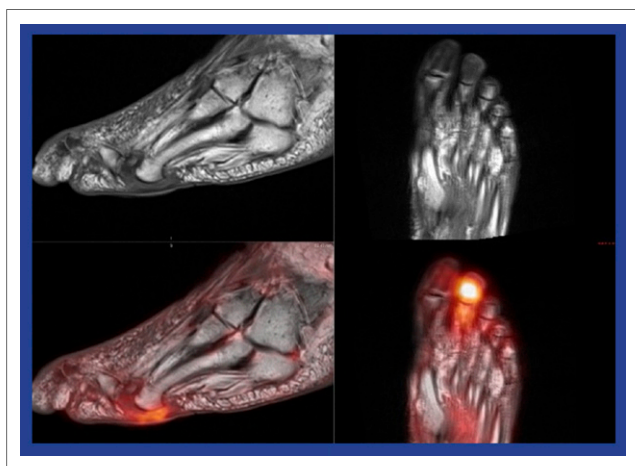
PET/MR and diagnosis of pedal osteomyelitis in diabetes. T1-weighted MR images of the foot (top) showed an extensive area of decreased signal in the soft tissues consistent with cellulitis but no classic areas of extensive decrease in signal intensity as seen in osteomyelitis. PET/MR imaging (bottom) was definitive, showing intense uptake in the soft tissues as well as involvement in the bone.
